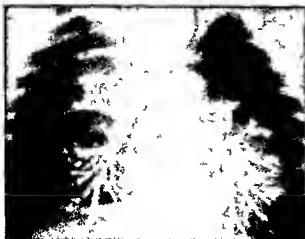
Esophageal atresia with distal fistula. An excess of barium was given by bottle and has been aspirated outlining the tracheobronchial tree. The barium was well tolerated and virtually gone in radiographs obtained an hour later.
